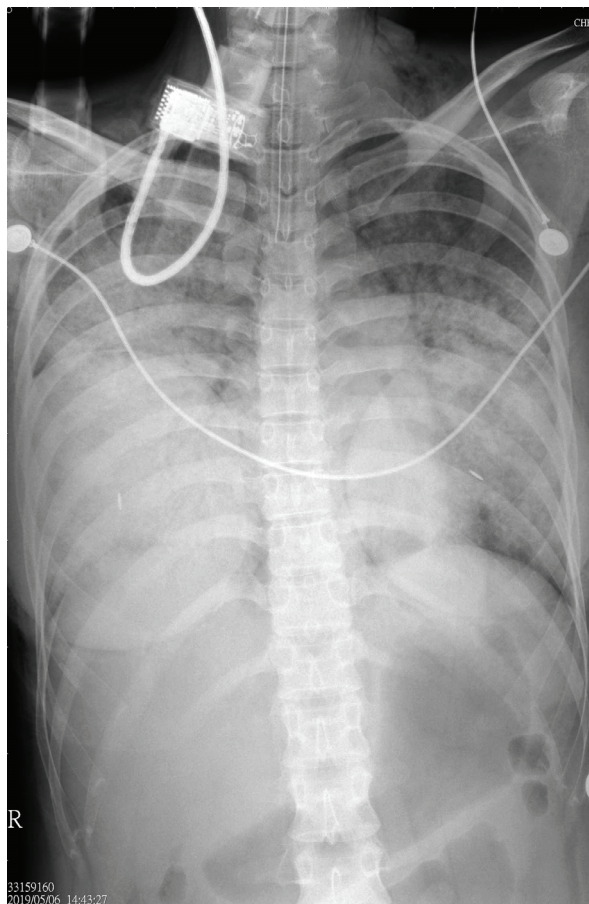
Chest X-ray showed bilateral dense consolidations with a central distribution and a nearly complete white-out of the right lung.
